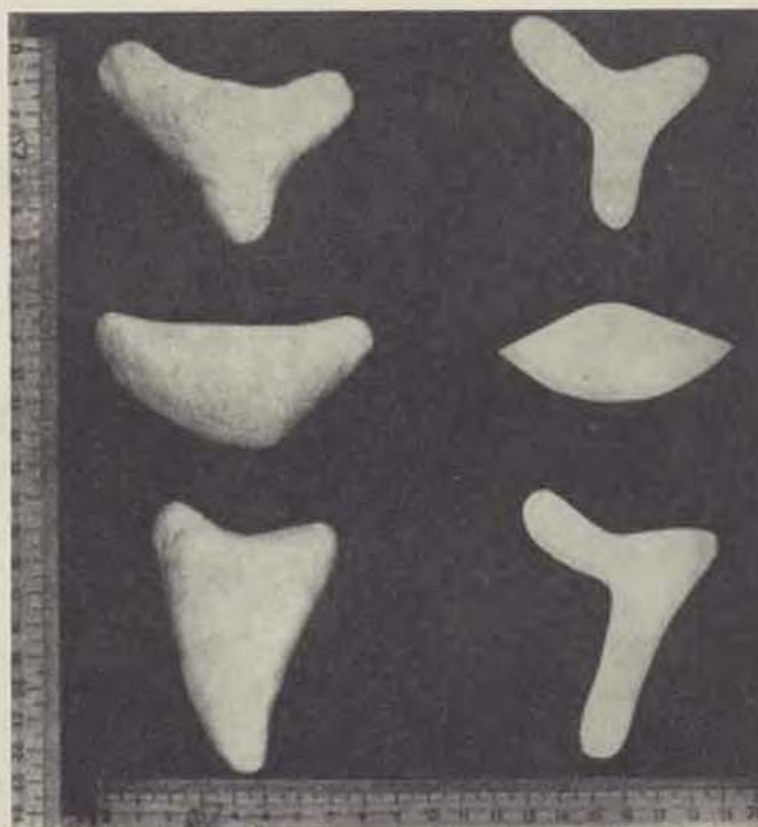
Individual models of wax (left) and patterns cut from X-ray films (right), prepared before operation
